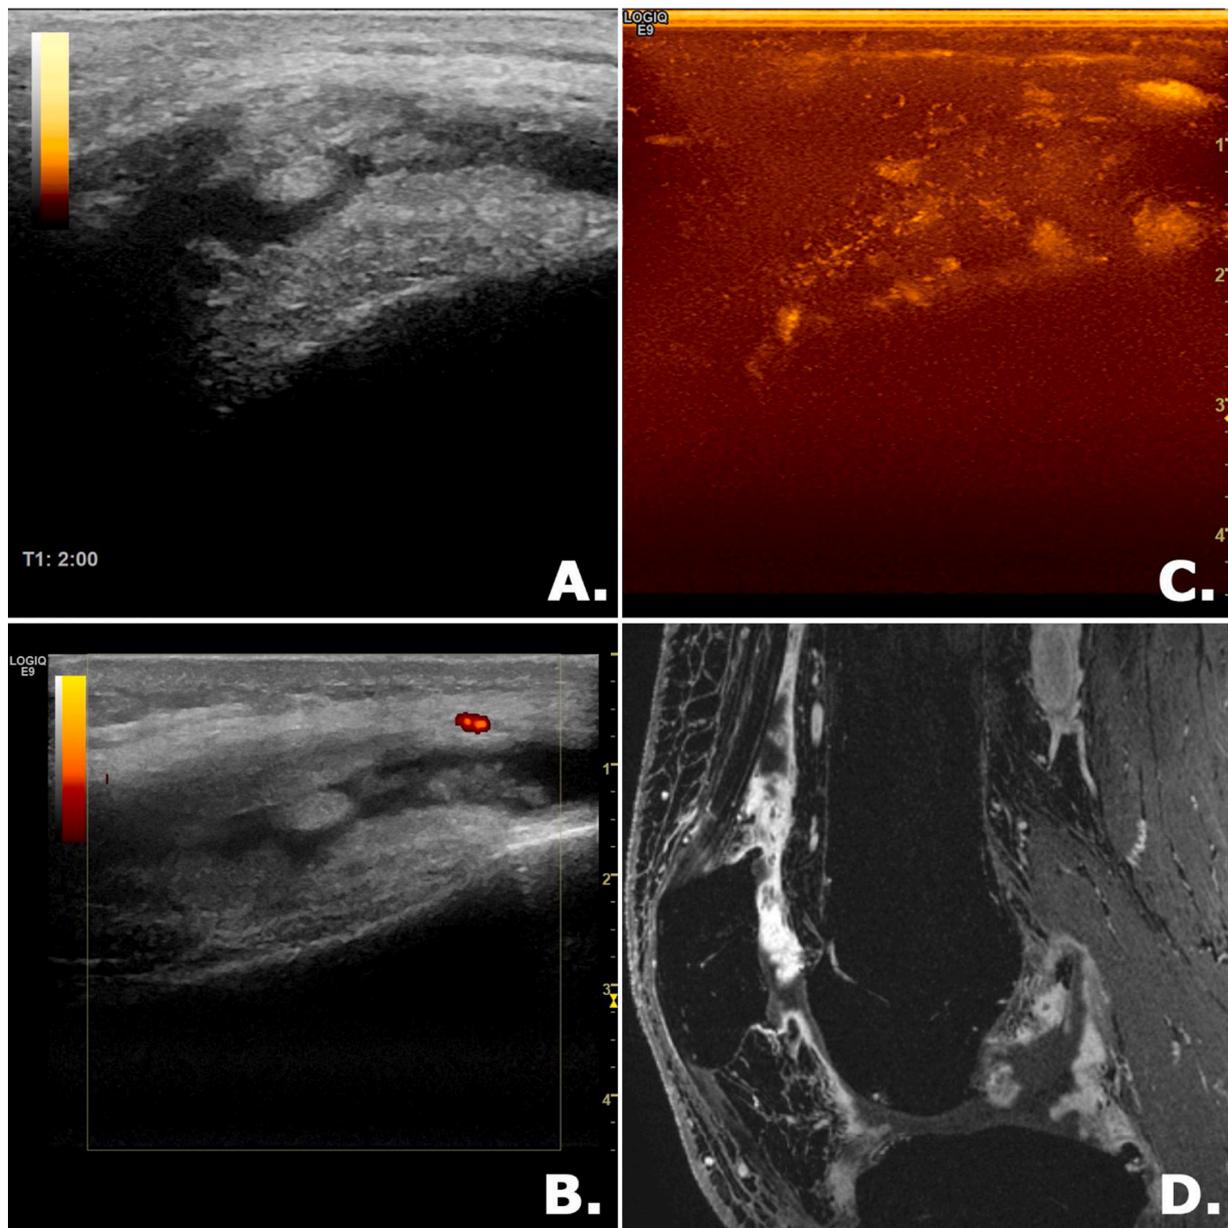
US and CE-MRI findings in a representative patient with KL grade 3 radiographic OA and severe synovitis. A: longitudinal GSUS image of the suprapatellar recess, reveals convex distention of the joint capsule by synovial fluid and hyperechoic synovial tissue. B: corresponding PDUS image of same patient, revealing less than 3 color signals. C: corresponding CEUS image, depicting a summed representation of the detected contrast microbubbles. D: sagittal image from CE-MRI showing severe synovitis in the same patient.
